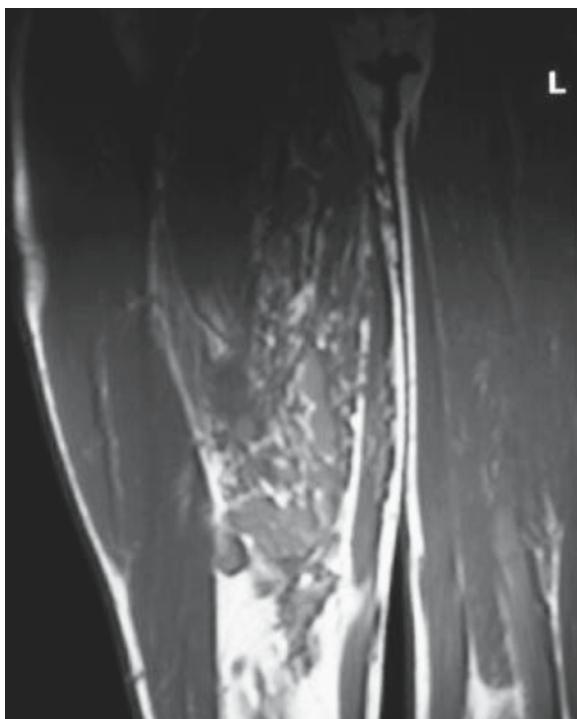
Coronal T1-weighted image of the right thigh shows an intramuscular mass which involves the hamstring muscles. The lesion is composed of multiple nodular components which make it resemble 'a bunch of grapes'
